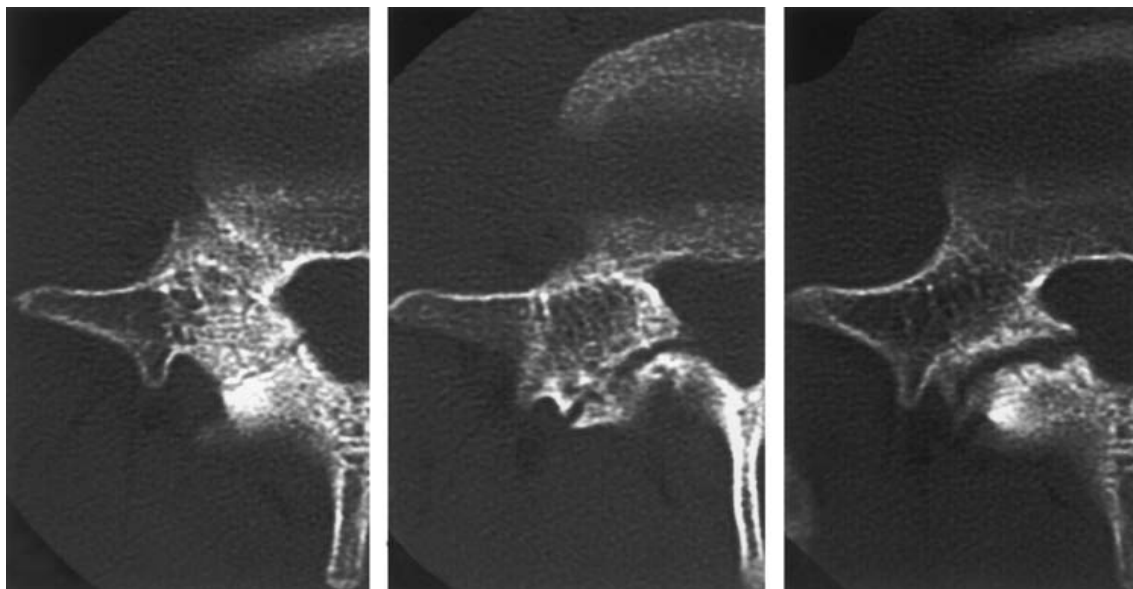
Representative CT images of stress fractures in a) the early stage, b) the progressive stage and c) the terminal stage.
